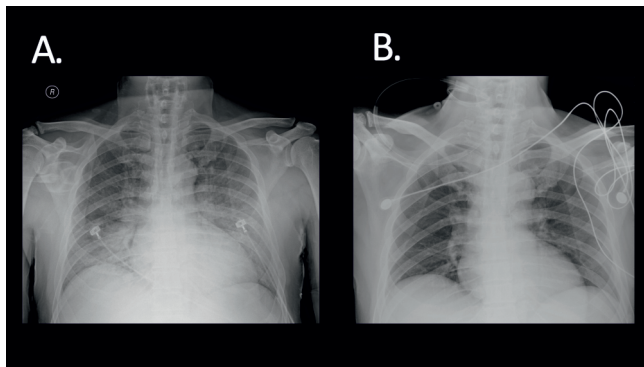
A. Roentgenogram of the chest on admission revealed bilateral pulmonary edema. B. Forty days after admission, the pulmonary edema had resolved.
